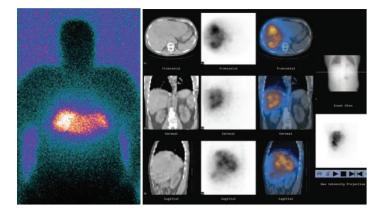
BremsstralungPlannar SPECT (right) and SPECT/CT (left) scanto confirm the placement of the microspheres in liver after treatment.
